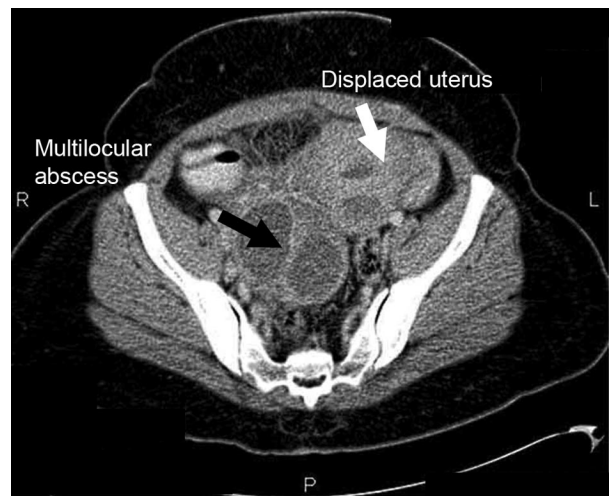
Postdelivery abdominal computed tomography scan revealing multiloculated abscess. This figure was published in Barton JR, Sibai BM. Management of severe sepsis and septic shock. In: Sibai BM, editor. Management of acute obstetric emergencies. 1st ed. Philadelphia (PA): Saunders, an imprint of Elsevier Inc; 2011. p. 93–100. Copyright © Elsevier, 2011.
